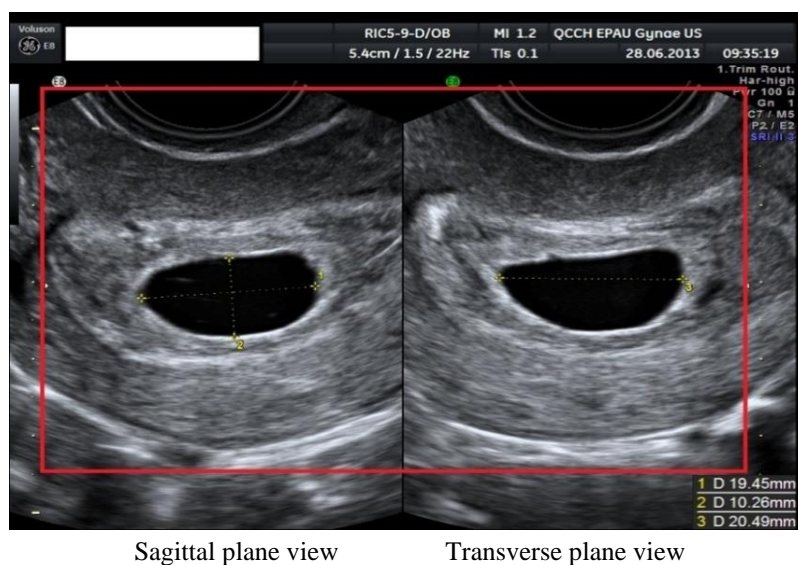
4: Ultrasound images of GS in Sagittal and Transverse planes
